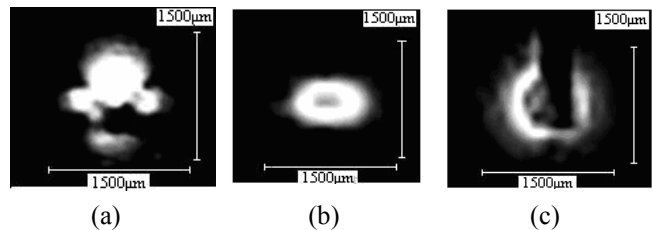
MRI images obtained at 4.7T: coronal plane (a) and transversal plane (b) are obtained and enable to evaluate the active volume of the planar micro coil.
